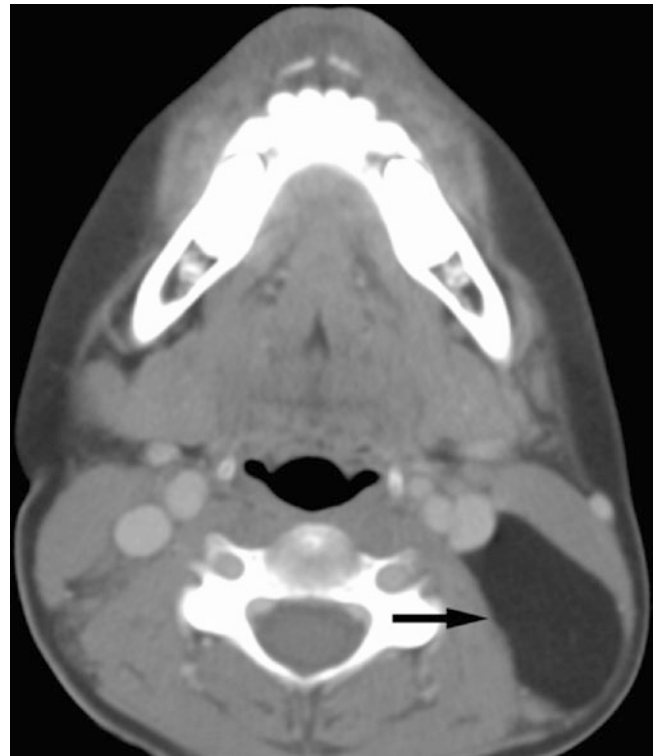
Lipoma; 8-year-old female with a 3-week history of left posterior neck mass. No redness, no fever, and no tenderness. Axial CT image shows low-attenuation well-circumscribed fatty appearing mass in posterior triangle of left neck (*arrow*), deep to sternocleidomastoid muscle
